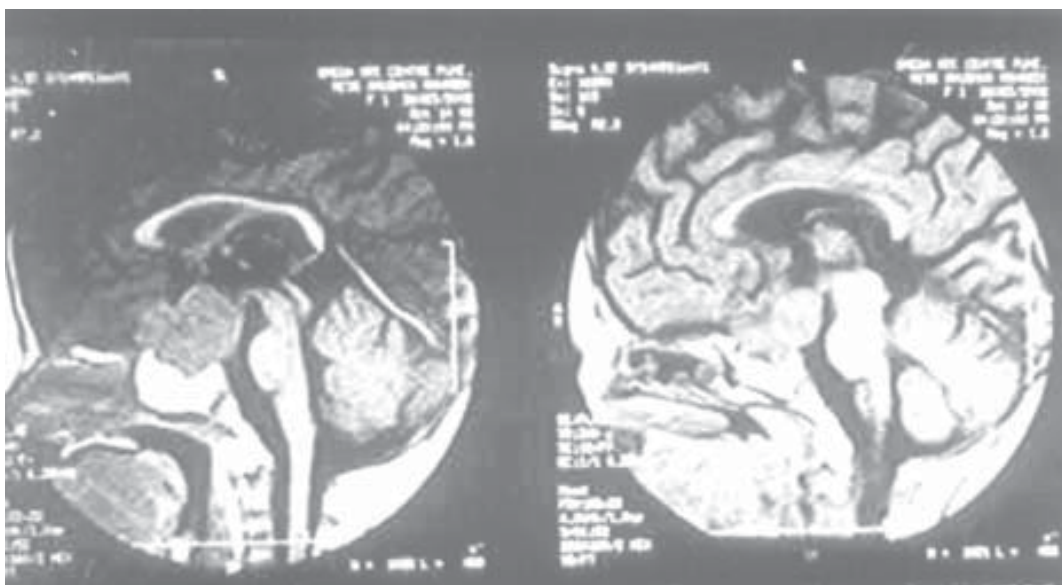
MRI showing large pituitary macroadenoma.
